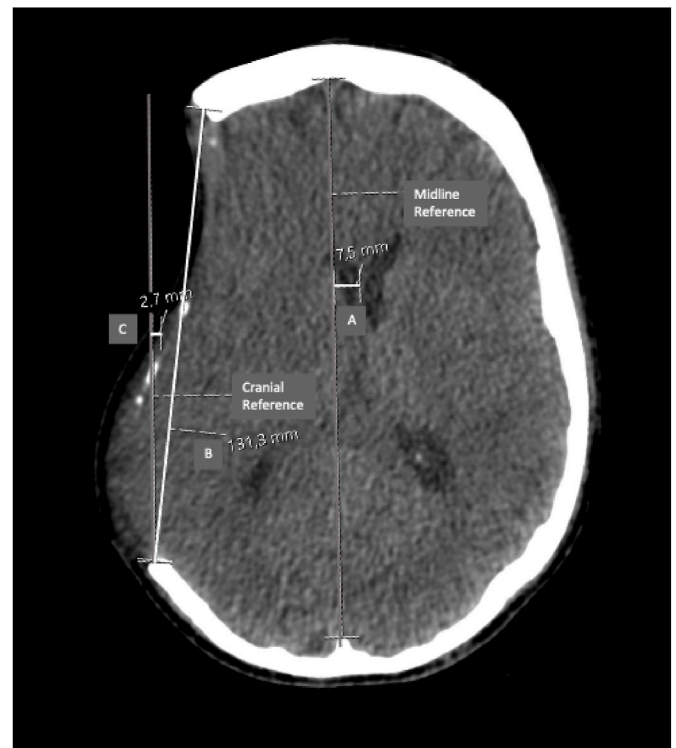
CT image showing the measurements of largest axial craniectomy dimension (B), positive *septum pellucidum* (A) and skin flap deviations (C).
